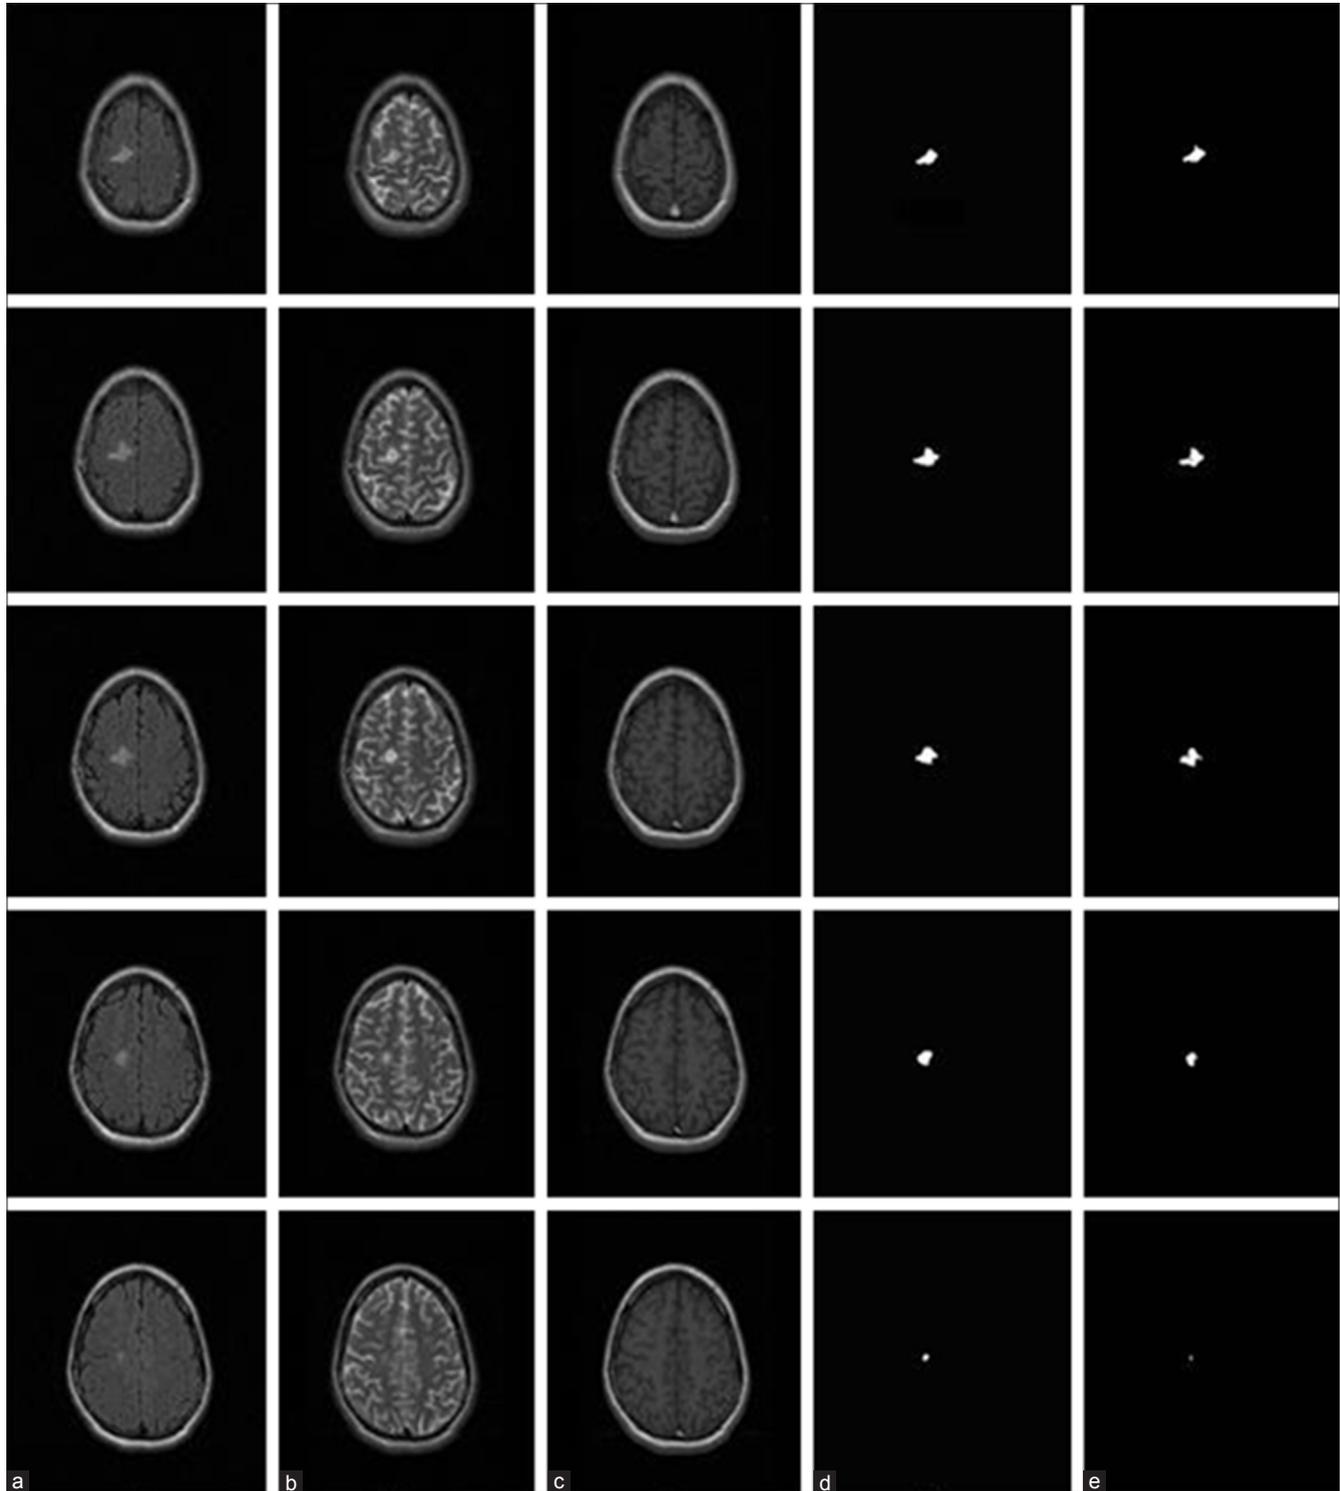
Segmentation of MS lesions in 5 slices of a real MR images. (a) Original FLAIR image; (b) Original T2 image; (c) Original T1 image, (d) Automatic segmentation of MS lesions by GA-SVM method; (e) Manual segmentation of MS lesions
